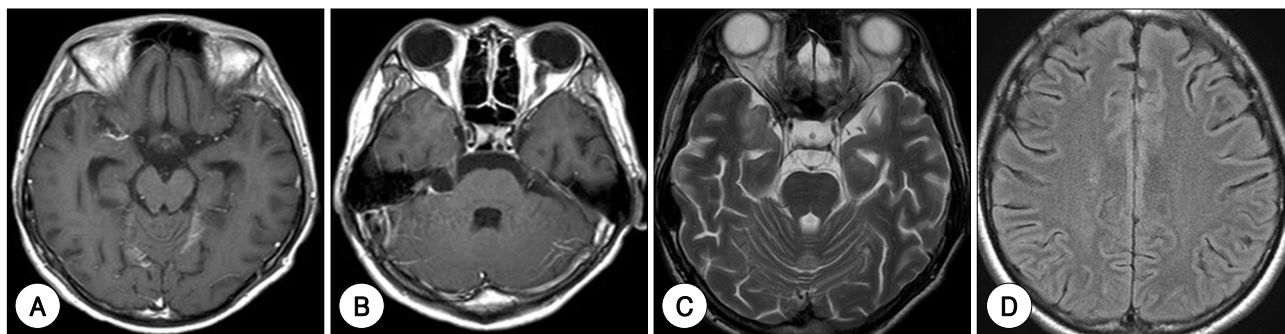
T1-weighted gadolinium-enhanced axial magnetic resonance images (MRI) scans showing enhancement of the mesial temporal lobe through the leptomeninges (A) and right trigeminal nerve (B). T2-weighted image showing high signal intensity on right mesial temporal lobe (C). FLAIR image showing high-signal intensity of bilateral cingulate gyri (D).
